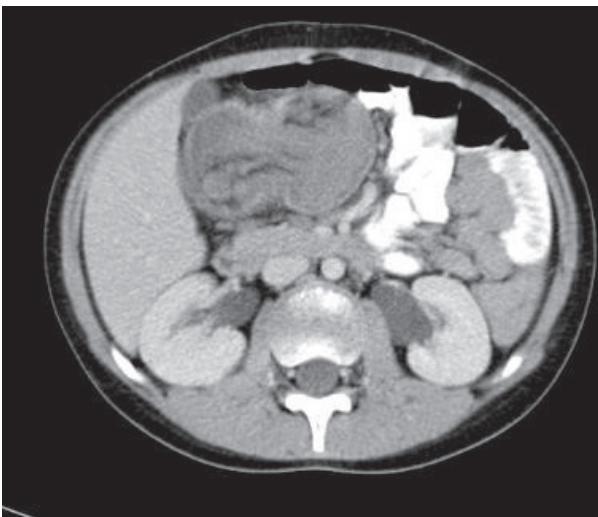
Axial CT scan at the mid-abdomen.
